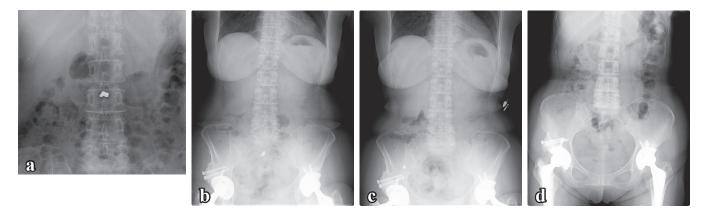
Posteroanterior abdominal radiographs showing a metal crown (case No.12). a: The metal crown located in the small intestine (jejunum) on the day of ingestion. b: The crown still located in the small intestine (ileum) 2 days after ingestion.c: Passage of the crown to the large intestine (ascending colon) 5 days after ingestion. d: Egestion of the crown 9 days after ingestion.
